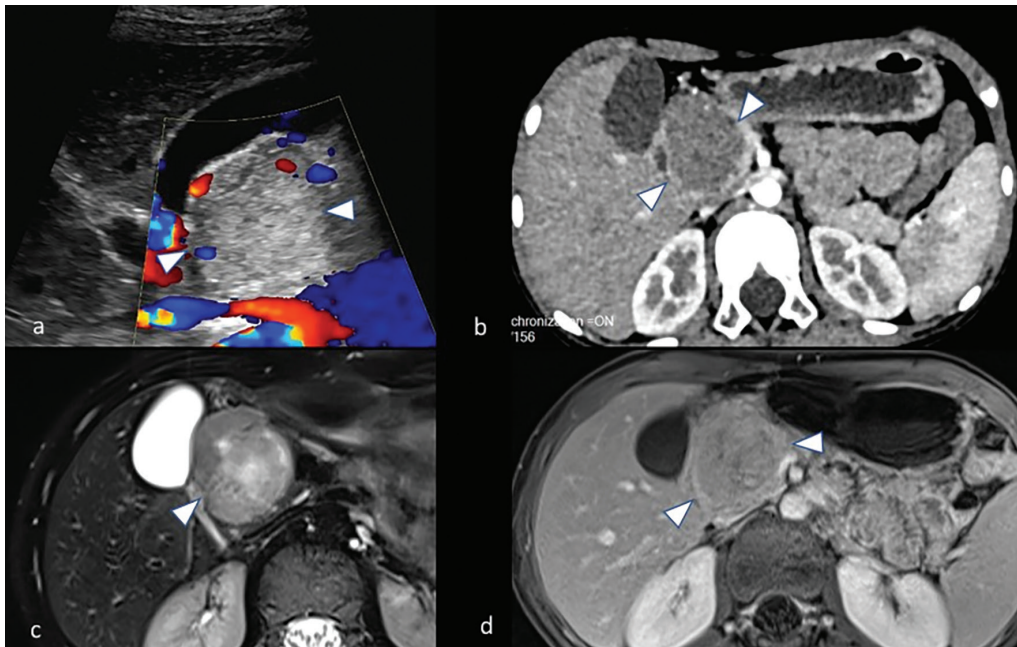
Solid pseudopapillary neoplasm of the pancreatic head in a 12-year-old male. (a) USG demonstrates a 42 × 37 mm well-defined mass with fine internal vascularity on Doppler interrogation. (b) Contrast-enhanced CT shows a heterogeneous solid mass with portal venous phase-dominant enhancement and less than 180° contact with the portal vein confluence and superior mesenteric vein. (c) T2-WI-MRI reveals heterogeneous signal intensity with central cystic foci. (d) Venous-phase contrast-enhanced MRI demonstrates heterogeneous enhancement. Posterior displacement of the inferior vena cava is noted; no peripancreatic lymphadenopathy was identified. Preoperative diagnosis was solid pseudopapillary neoplasm, confirmed on surgical pathology.
